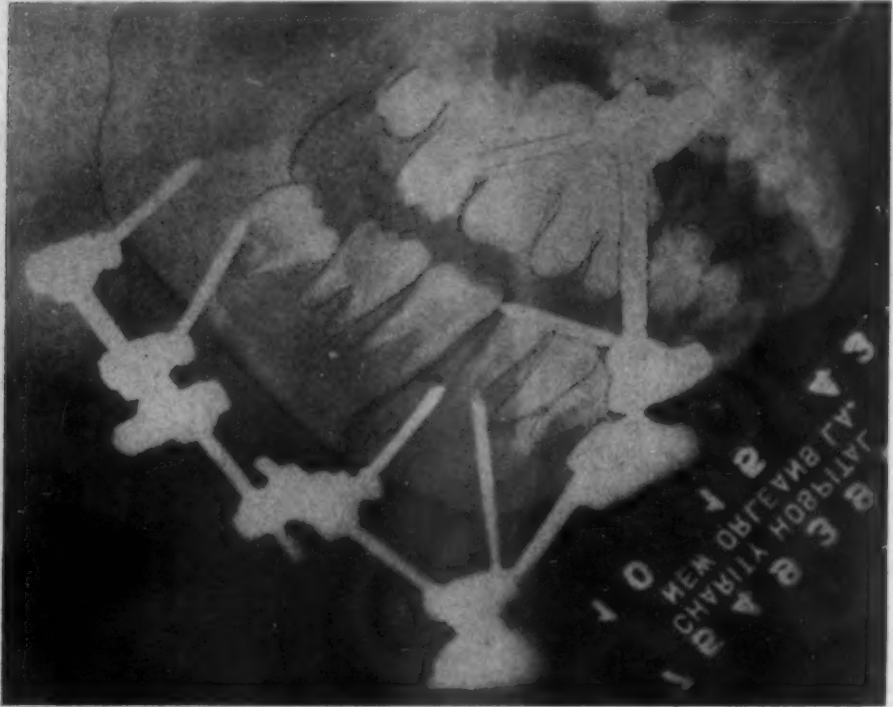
Lateral radiographic view of the Roger Anderson appliance in position.
